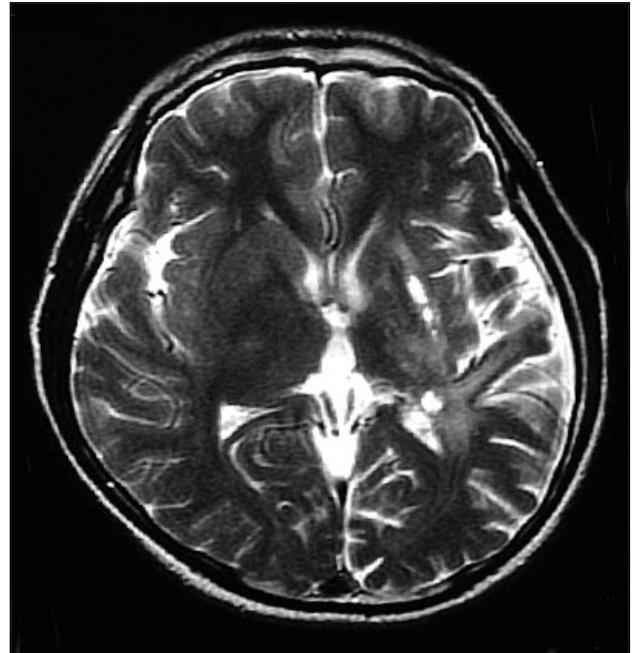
Axial T2-weighted magnetic resonance imaging at the level of the basal ganglia shows extension of the hyperintense lesion to involve the whole lentiform nucleus, and the posterior limb of the internal capsule to the ventromedial aspect of the thalamus. There is volume loss in these regions and the foci of hypertensity are enlarged.
